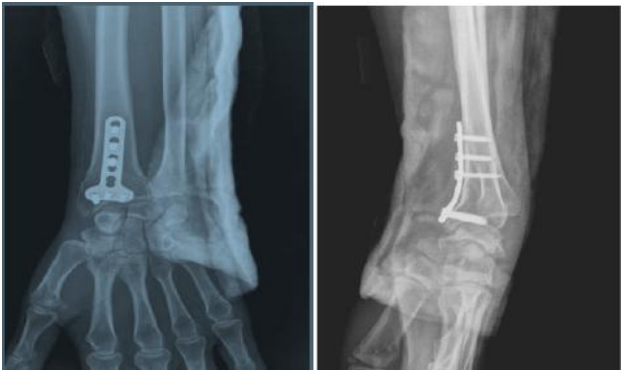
Follow-up X-ray at 6 weeks
